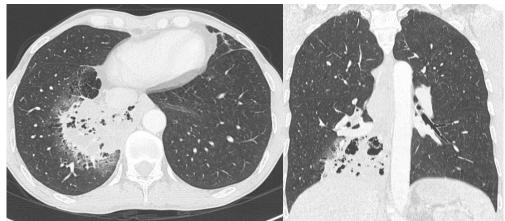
Chest CT scan lung windows in axial and coronal cross sections show a large mass in the right lower lobe with cysts and excavation areas
